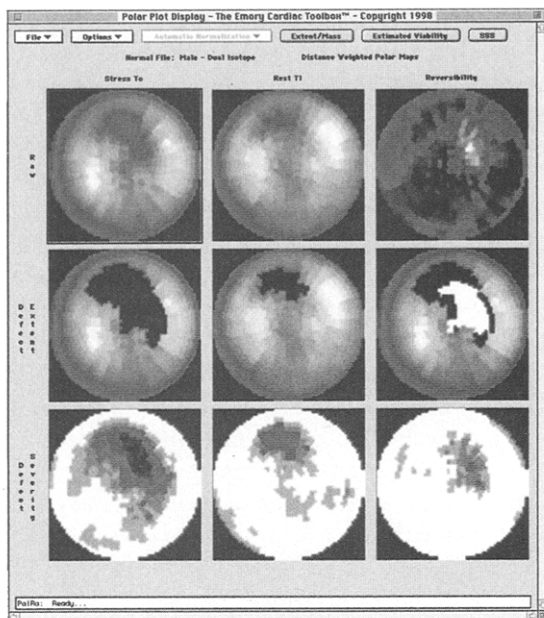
Polar map representations of SPECT images. The maps show stress and rest perfusion and reversibility, in a normal representation (A) and in representations that are designed to represent defect extent (B) and severity (C).
